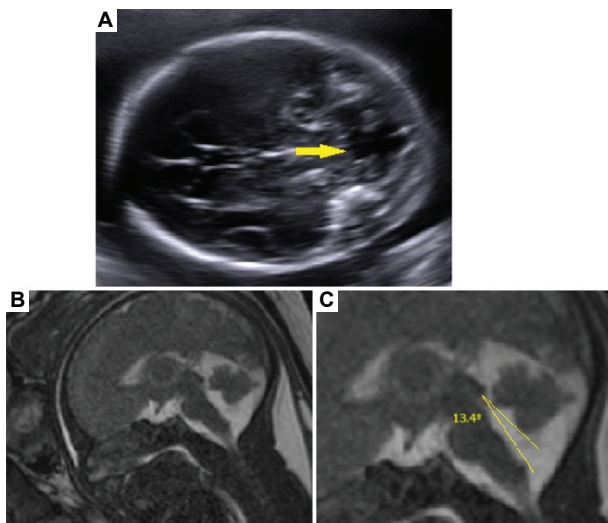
Blake's pouch cysts imaging in a 33-week fetus. (A) Axial ultrasound image shows Blake's pouch cyst (yellow arrow). (B and C) Sagittal HASTE and TRUFI images demonstrate a normal-sized and well-configured vermis with a slightly increased tegmentovermian angle. Abbreviations: TRUFI: True fast imaging with steady-state free precession; HASTE: Half-Fourier acquisition single-shot turbo spin-echo.
